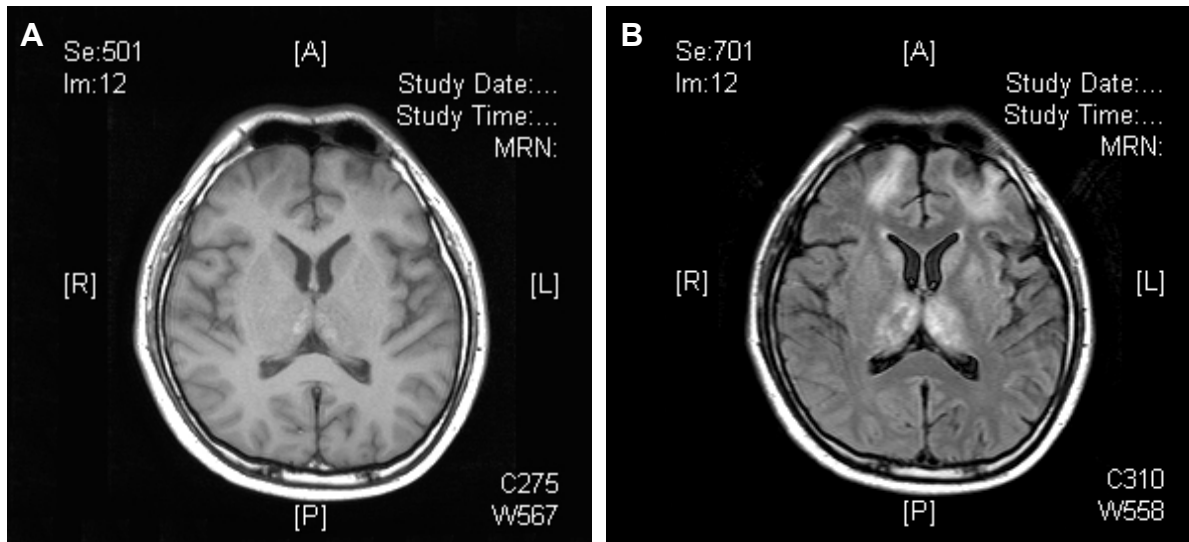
Brain magnetic resonance imaging 3 weeks later on (A) T1WI and (B) FLAIR, showing less brain edema, but hemorrhagic formation in bilateral thalami, new high T1WI signal.
